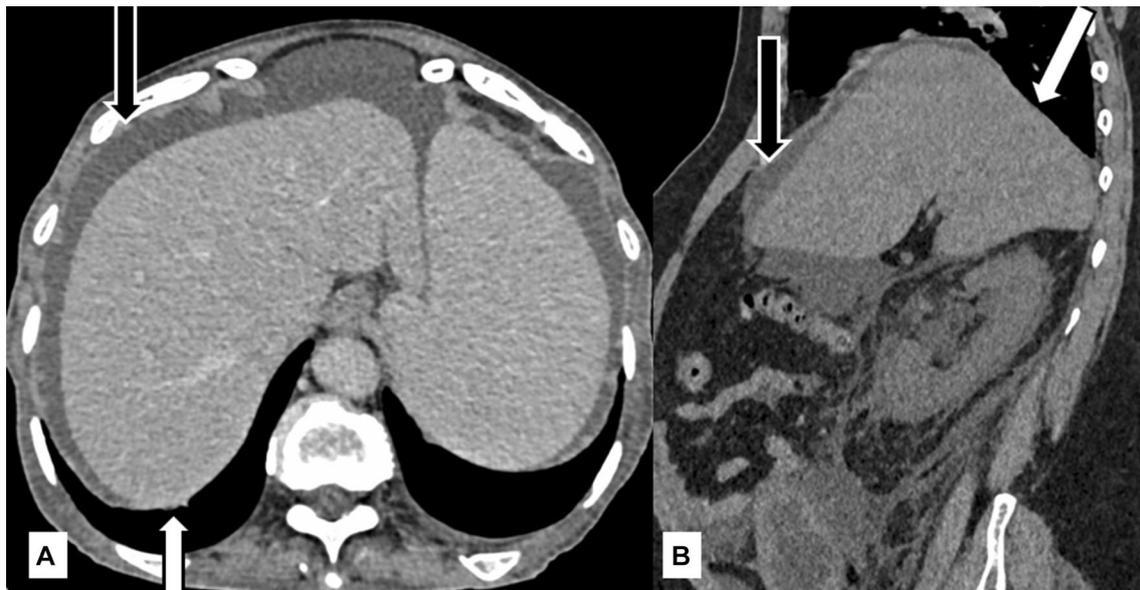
Axial contrast-enhanced CT section (a) and sagittal reformat (b) show the bare area of liver abutting the diaphragm (white arrows) and ascites (black arrows) which does not cover the bare area
